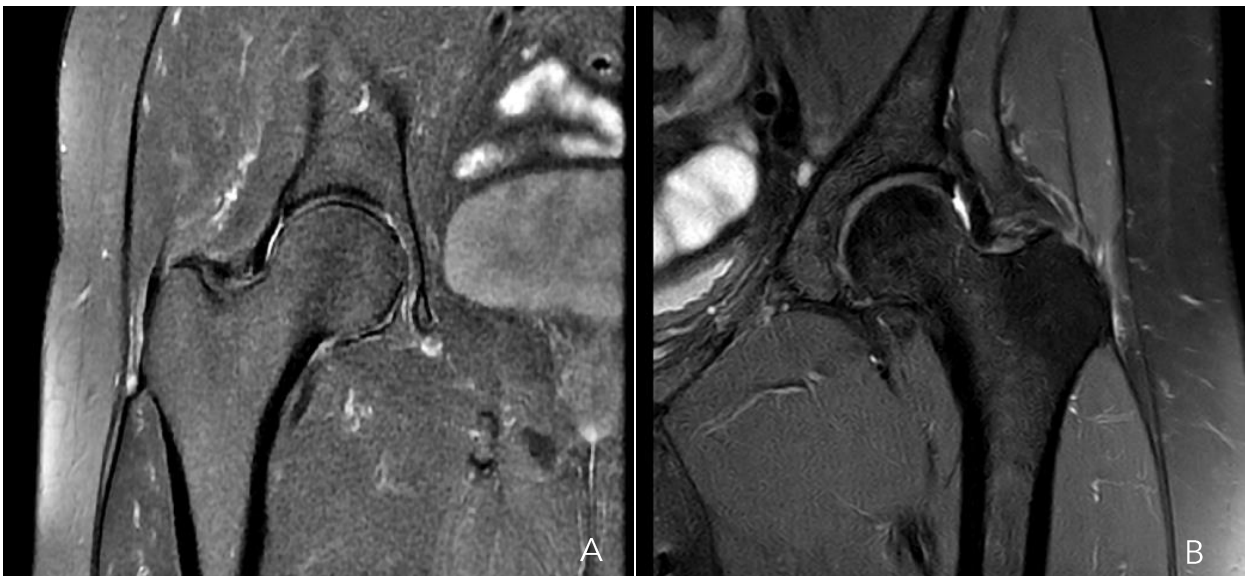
MRI of right (a) and left (b) hips with gluteus medius tendinitis
